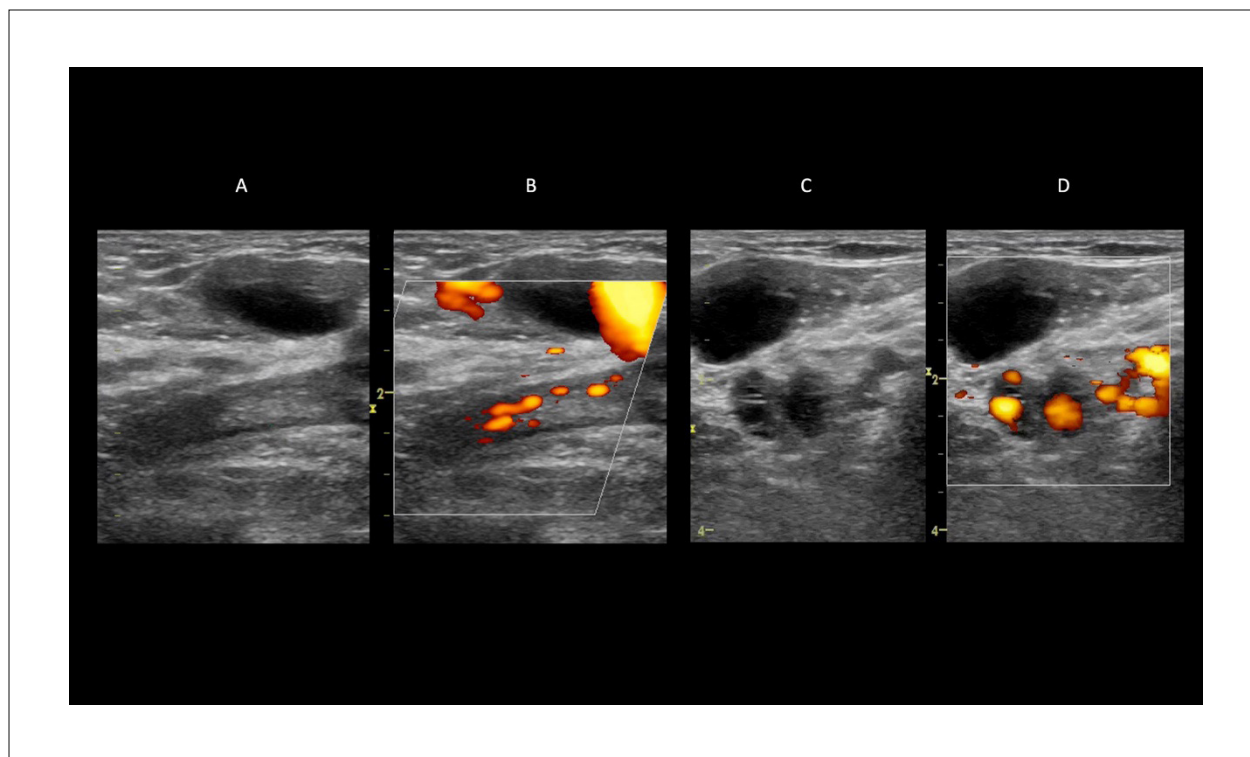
Chronic post-thrombotic changes. A: B-mode image showing no dilation of the femoral vein. Echogenic luminal image consistent with chronic post-thrombotic changes; B: power Doppler image showing reduced luminal flow; C: B-mode image showing posterior tibial veins with thick walls; D: power Doppler image showing partial luminal narrowing of posterior tibial veins.
